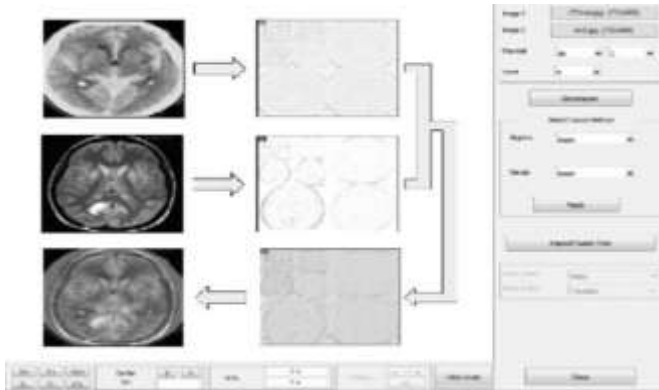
Fusing MRI and CT images using Python wavelet tool.
